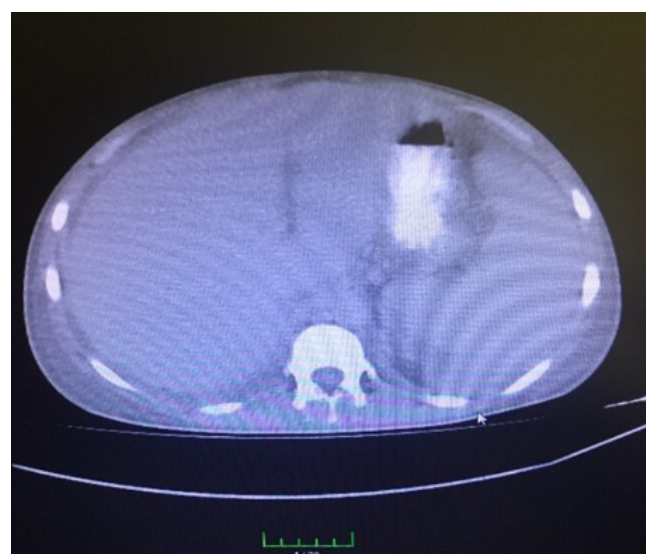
Abdomen CT image of case 1 at the time of diagnosis showing subcutaneous edema.
